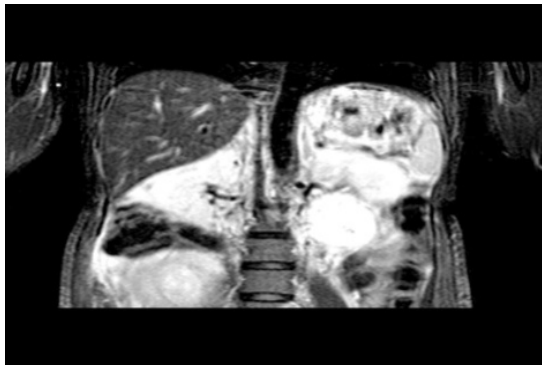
MRI Abdomen and pelvis.
